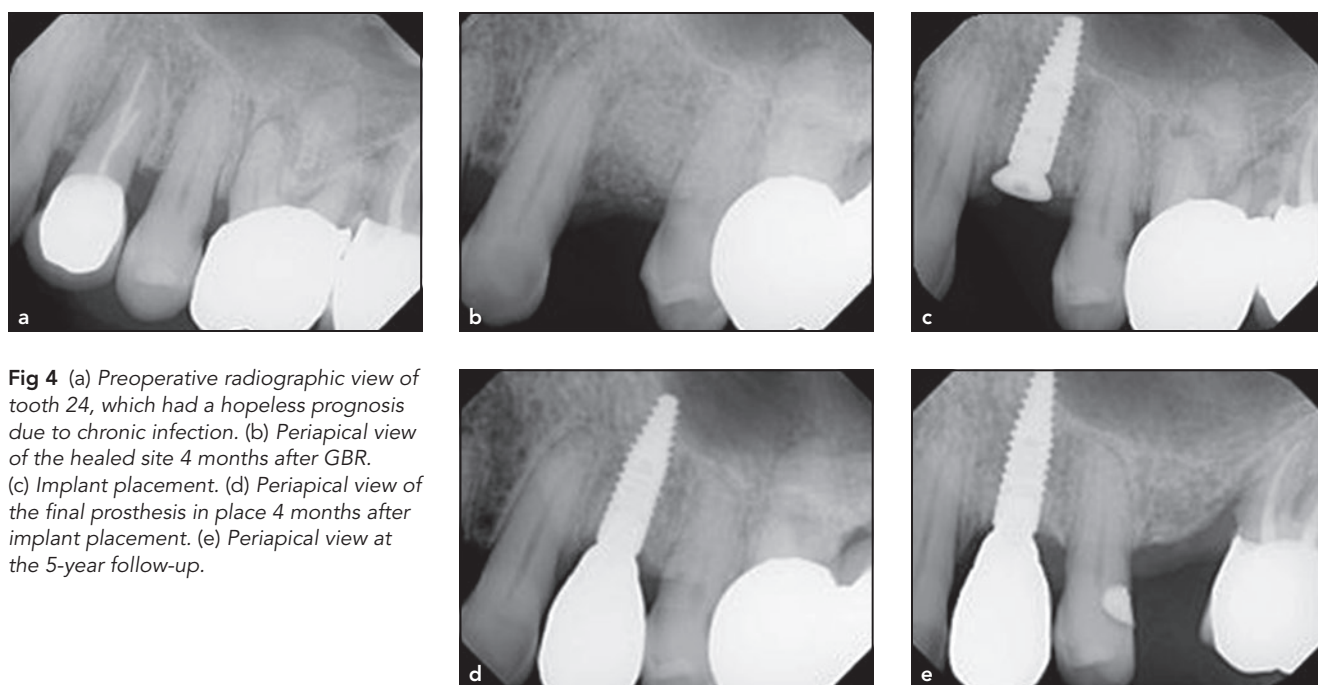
(a) Preoperative radiographic view of tooth 24, which had a hopeless prognosis due to chronic infection. (b) Periapical view of the healed site 4 months after GBR. (c) Implant placement. (d) Periapical view of the final prosthesis in place 4 months after implant placement. (e) Periapical view at the 5-year follow-up.
